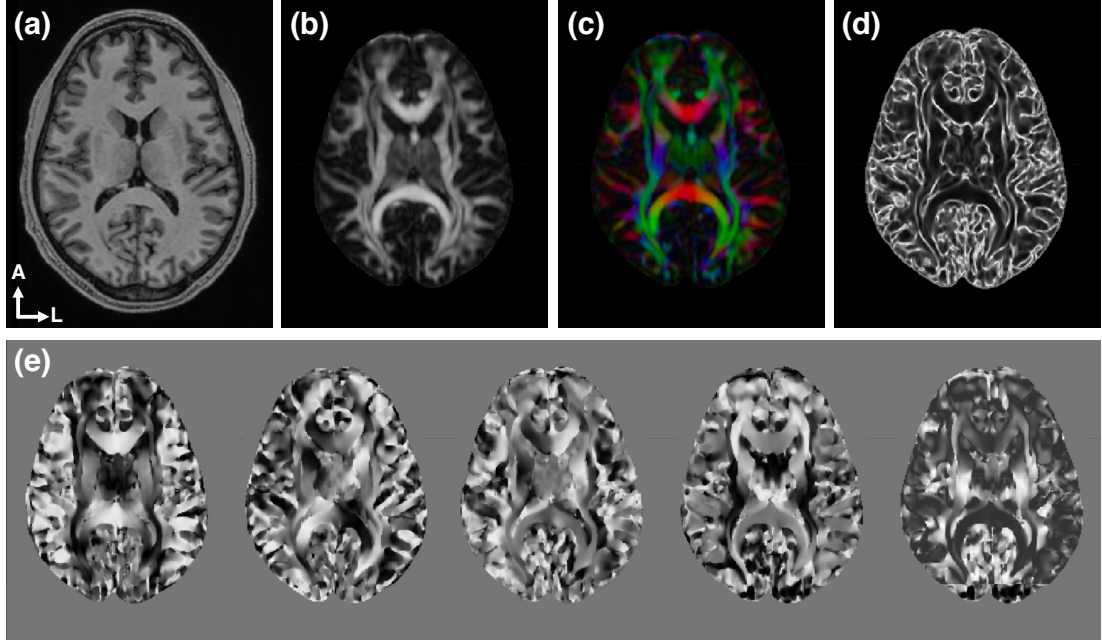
T1-w MR image and DTI feature images. (a) An axial slice of a T1-w MRI. (b) Fractional anisotropy (FA) image. (c) FA colored by primary eigenvector. (d) Knutsson edge map. (e) Knutsson 5D image.
